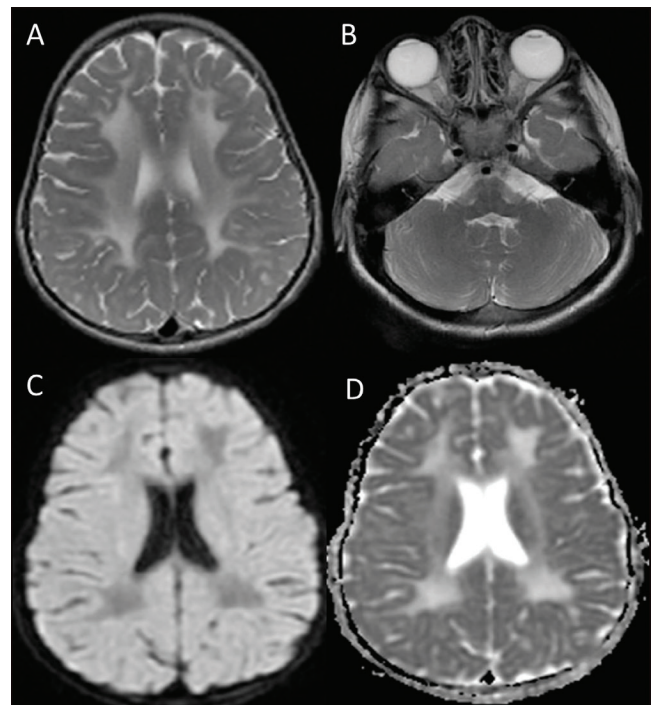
(A) Axial T1-weighted image showing diffuse hypointensity of the supratentorial white matter, resulting in blurred gray-white matter interface, consistent with hypomyelination. (B) Axial T2-weighted image showing diffuse white matter hyperintensity with hypomyelination and cortical cerebral atrophy. Due to cerebral atrophy seen ventricular enlargement. (C, D) Axial DWI and ADC showing shrunken white matter with markedly increased diffusivity
